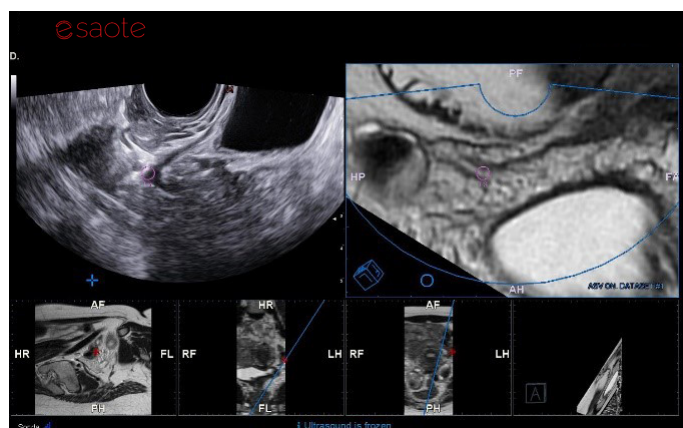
In the navigation phase the device is ready to navigate through real-time US and MRI.
